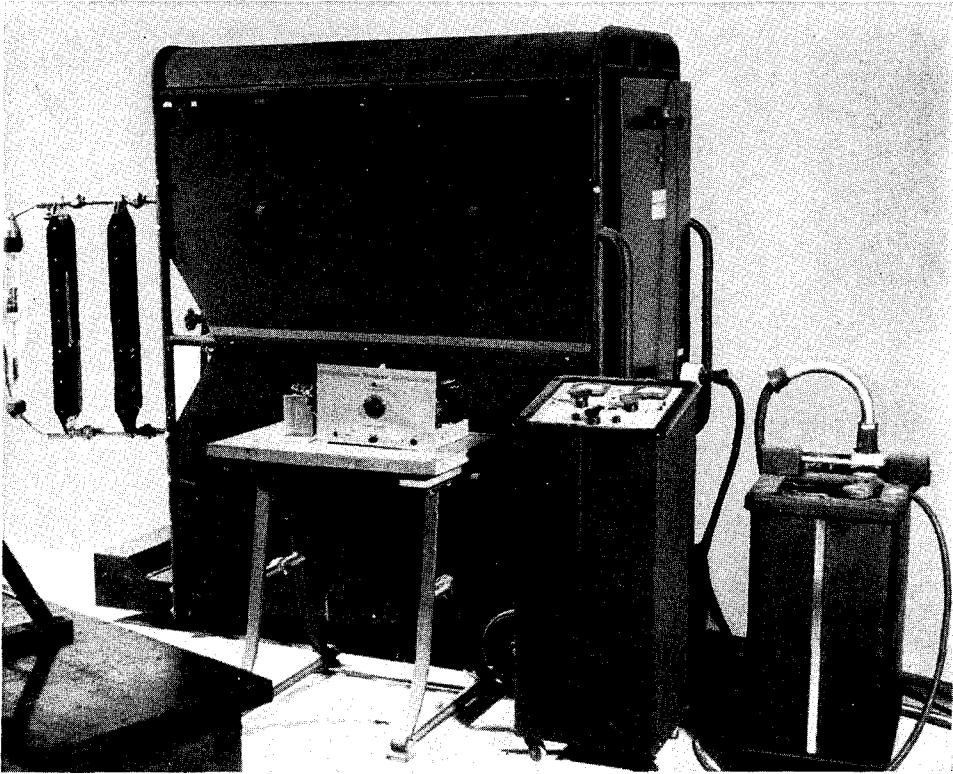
Westinghouse Micronex apparatus for X-ray pictures with exposure of one-millionth of a second. The X-ray tube is at left and the large surge generator containing banks of high-voltage condensers in the middle. In front of the surge generator (from left to right) is the trigger-delay circuit, the control box, and the high-voltage transformer.
